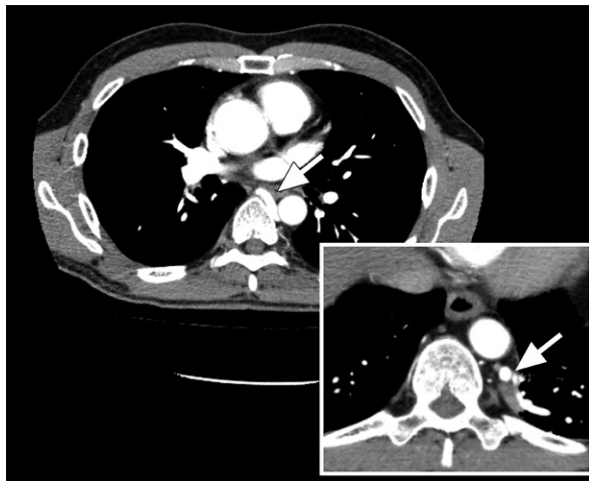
Patient 2. Computed tomogram shows drainage of the extralobar pulmonary sequestrum through a hemiazygos vein (arrow). The inset shows pulmonary venous drainage (arrow) at the level of the sequestrum.
